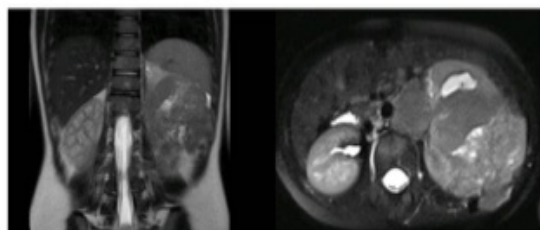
MRI image of the mass.
